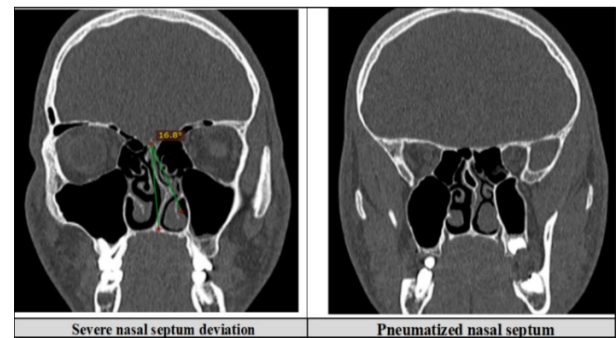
Coronal CT showing severe septal deviation and a pneumatized vertical ethmoidal plate.
